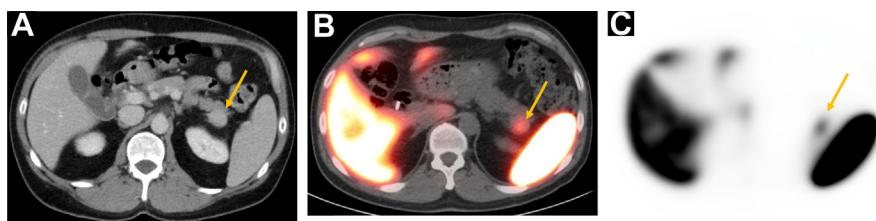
Enhancing lesion in the pancreatic tail (arrow) on contrast-enhanced CT of the abdomen (A). $^{99\text{m}}\text{Tc}$ -heat denatured RBC scan, fused transaxial SPECT/CT (B) and SPECT only images (C) show uptake in the lesion confirming splenule.
